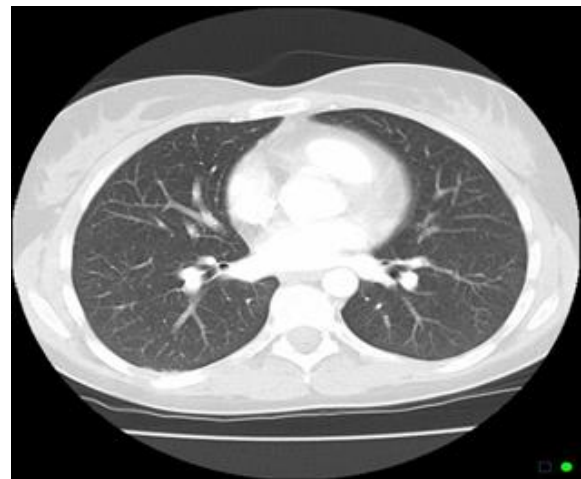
Normal Chest CT scan
